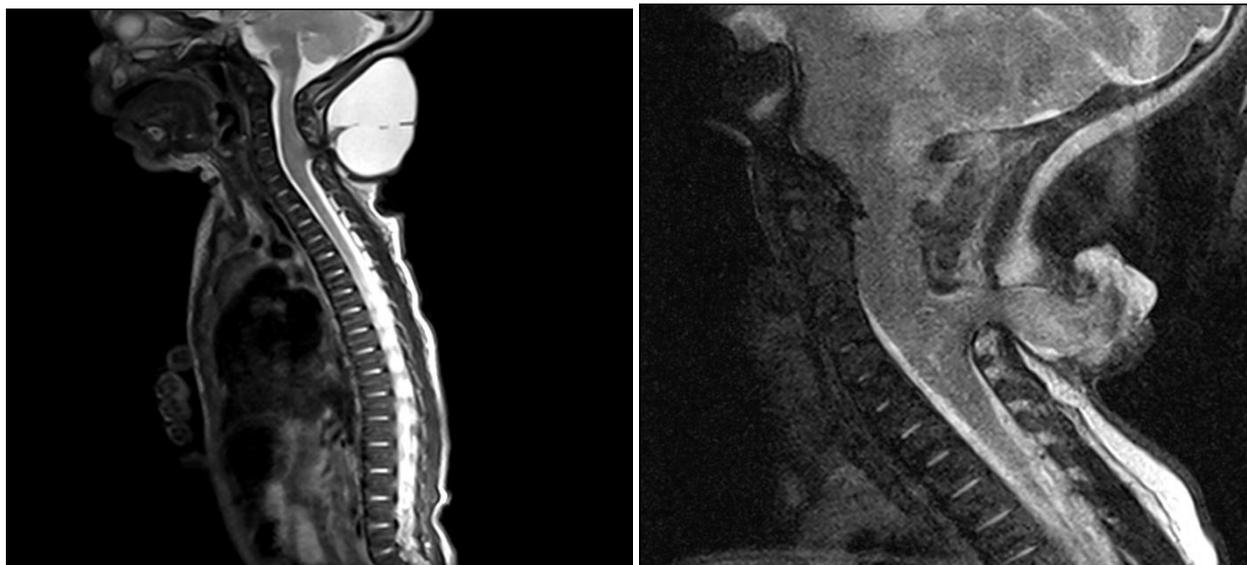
Sagittal MRI of Cervical Meningomyelocele
